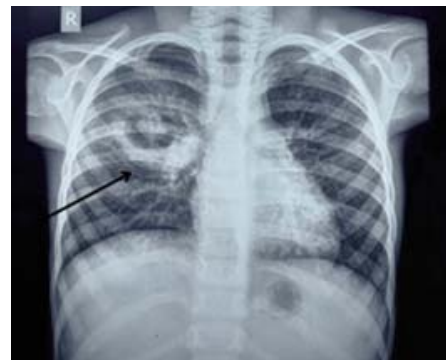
Chest X-ray, frontal view revealing non-homogenous opacity in the right middle zone, around radiolucent area with defined margin suggestive of lung cavitation.
